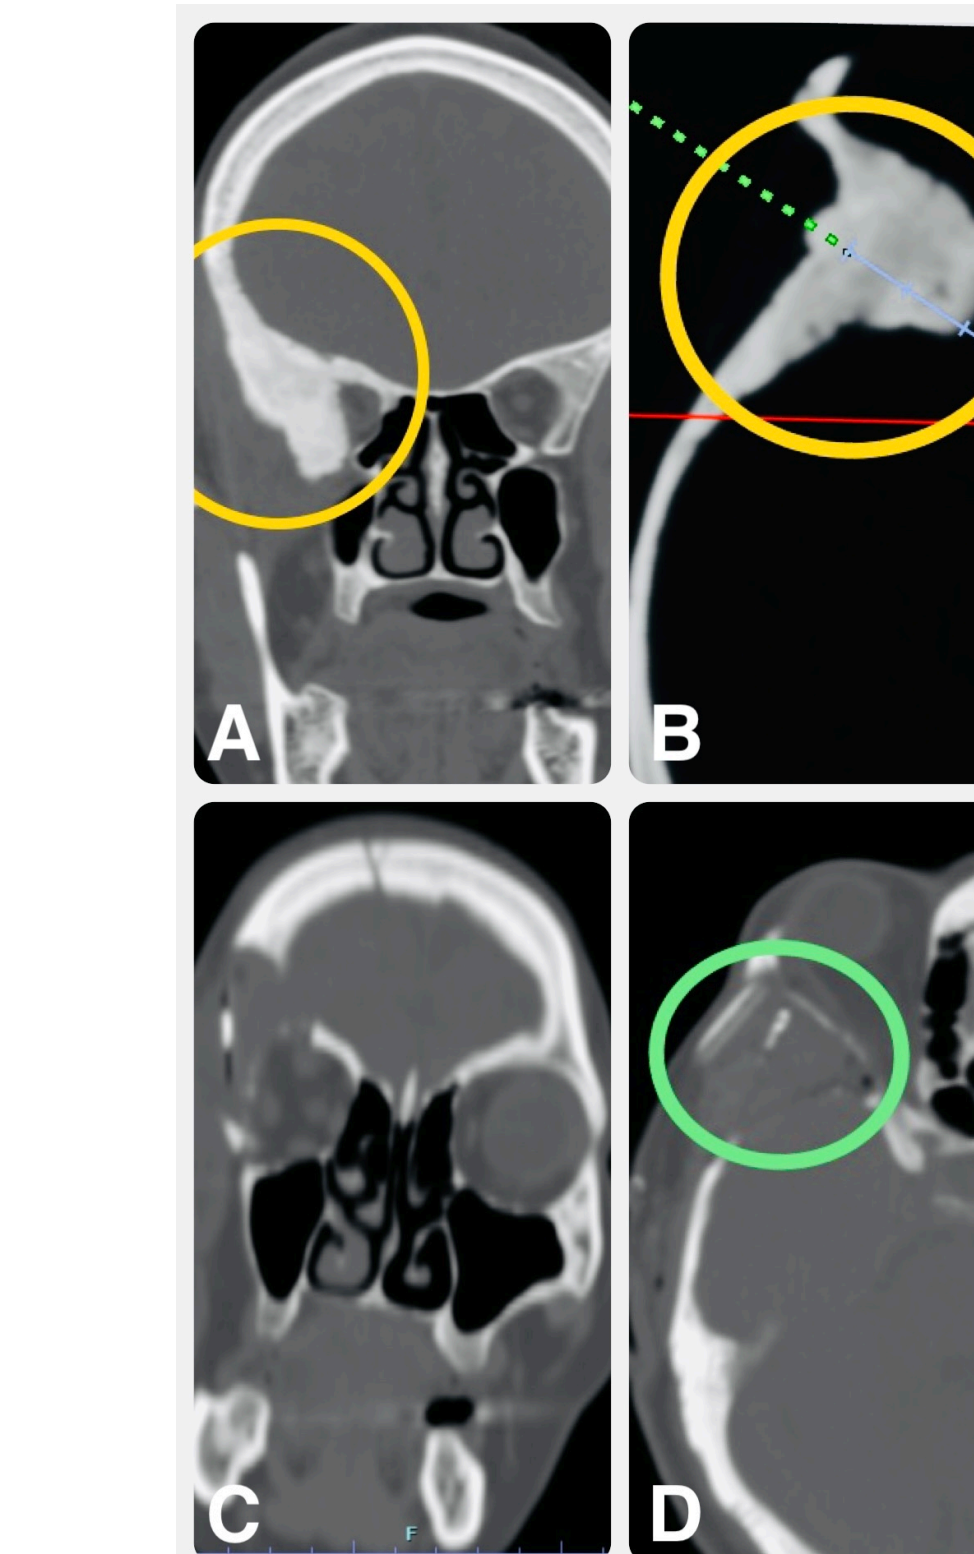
Preoperative and Postoperative CT Imaging
